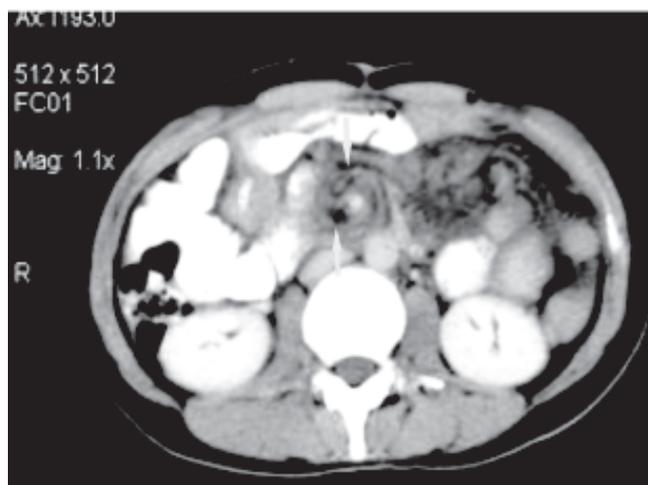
Contrast - enhanced CT scan showing "whirlpool sign"
